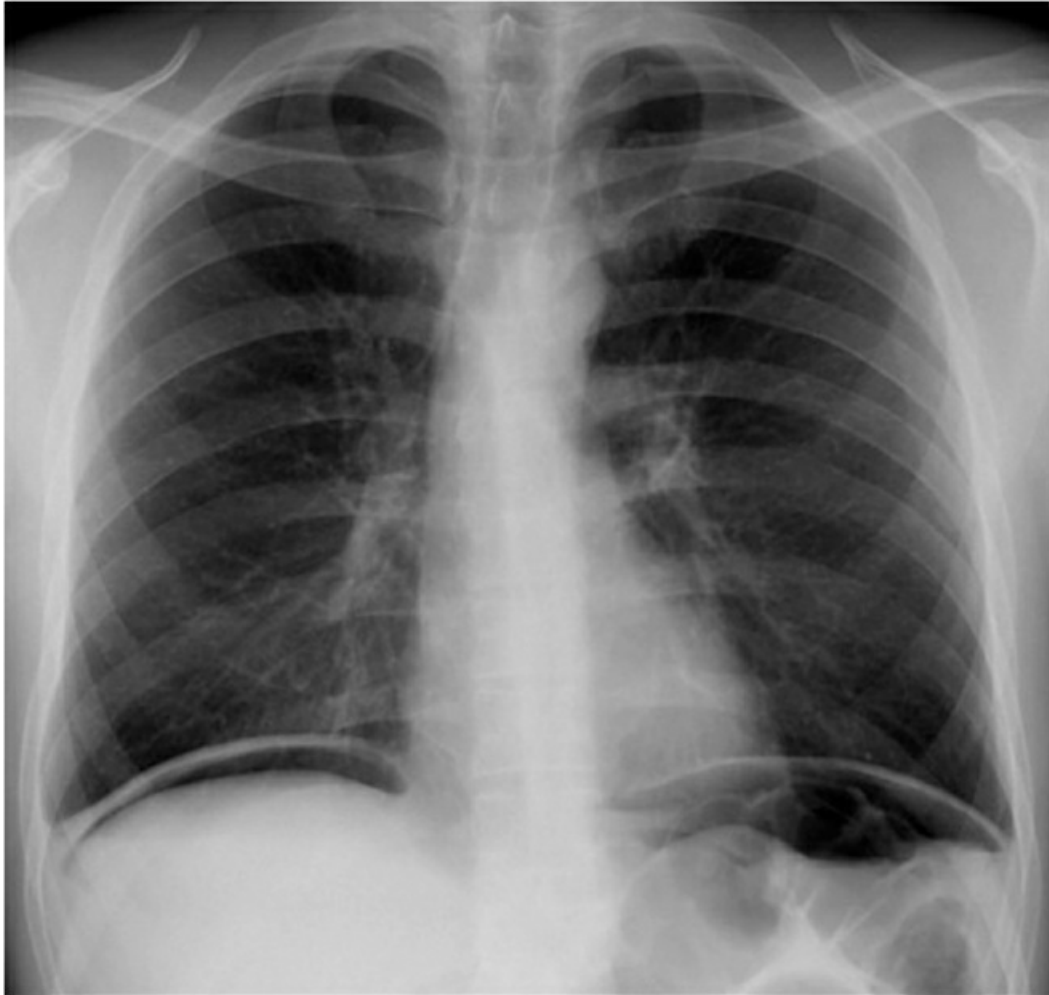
A chest x-ray in the upright position showing free air under both hemidiaphragms.
